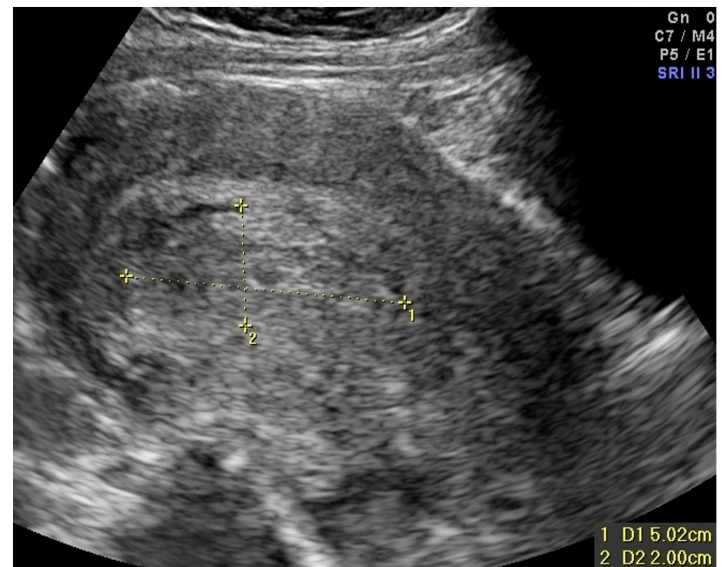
Ultrasound showing evidence of retained products of conception, demonstrated by echogenic, heterogeneous, and vascular intrauterine contents. Case courtesy of Dr Alexandra Stanislavsky, Radiopaedia.org, rID: 13852. Accessed at <https://radiopaedia.org/cases/retained-products-of-conception-2?lang=us>.
